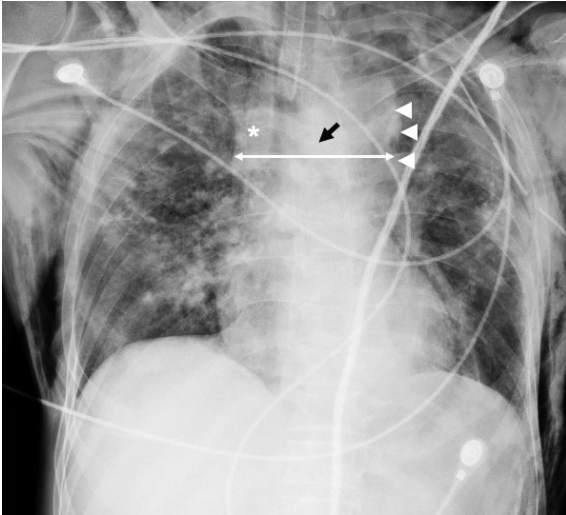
Chest X-ray depicting mediastinal widening (double arrow) at the level of the aortic knob, along with obscuration of aortic contours (arrowheads) in a posttraumatic patient. Note the right paratracheal stripe widening (asterisk) and the depression of left mainstem bronchus (black arrow). The findings are highly indicative of aortic injury.
